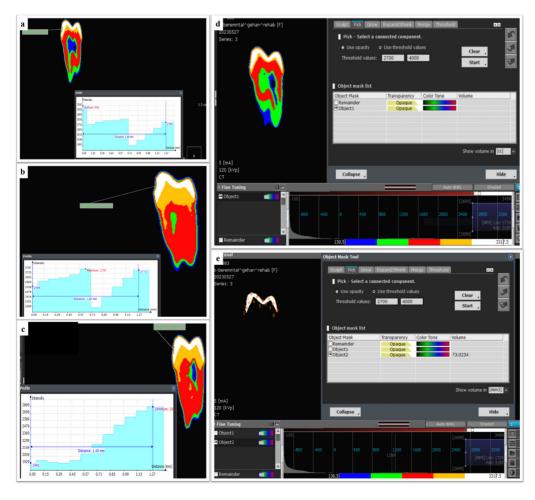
Measurement of enamel density of the middle of the buccal region by CBCT at:(a) baseline value, (b) after demineralization, (c) after remineralization. (d) determining the region of interest to measure enamel volume. (e) measurement value of the volume after selecting region of interest.
